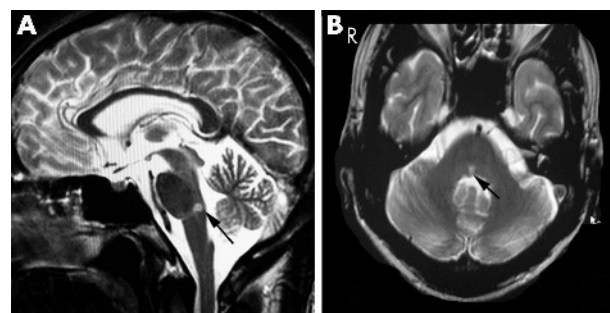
(A) Right paramedian tegmental pontine infarct seen on the T2 weighted sagittal magnetic resonance imaging (arrow). (B) The same lesion in transaxial T2 weighted sequence (arrow).
